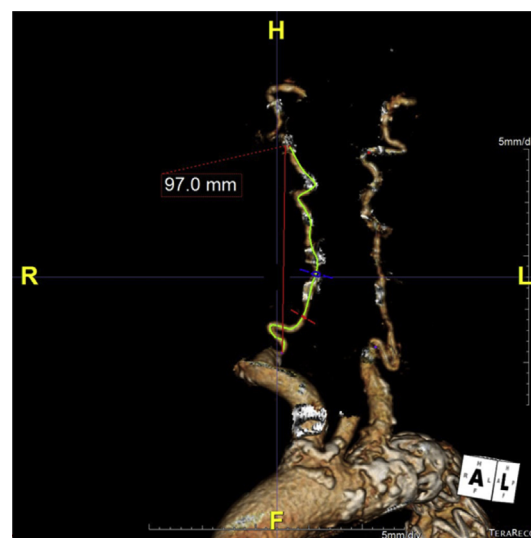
Straight line and tortuous line paths for determination of VTI in CT scans. The calculation is performed using the formula: $[(\text{centre-line distance}) / (\text{straight-line distance}) - 1] \times 100$. Given that the centre-line distance is 138 mm and the straight-line distance is 97 mm, the VTI is 42 in this patient.
